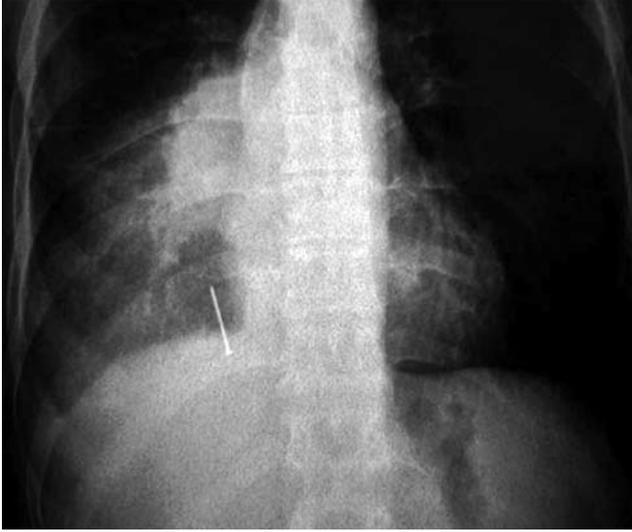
Chest X-ray showing a foreign body.
